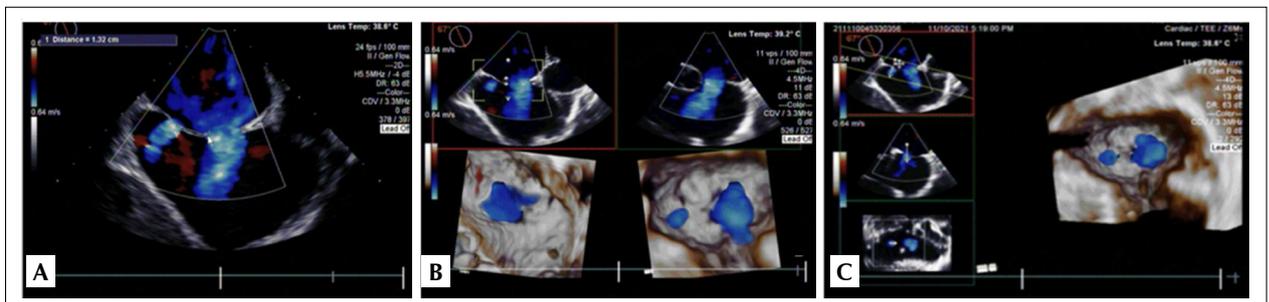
Three-dimensional transesophageal echocardiogram taken on November 11, 2021, showing an ostium secundum atrial septal defect (2 fenestrations) with hemodynamic repercussions.
